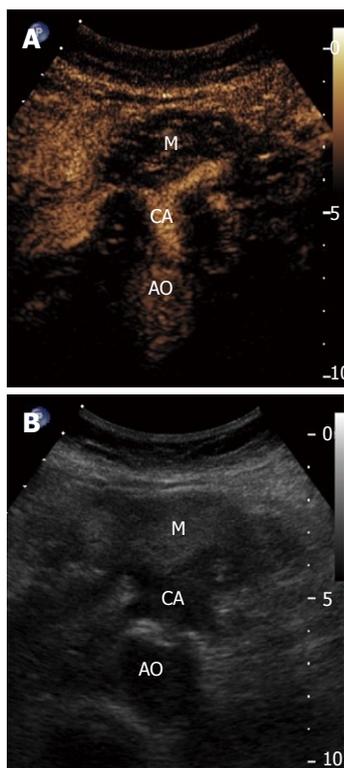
Transabdominal contrast enhanced ultrasound. A: Hypoechoic lesion in the head of the pancreas on traditional grey-scale ultrasound. B: Vascularity of this lesion after injection of Definity contrast agent. The ultimate diagnosis later proved to be pancreatic adenocarcinoma encasing the celiac axis. AO: aorta; CA: celiac axis; M: mass. Image courtesy of Dr. Stephanie Wilson, Department of Radiology, University of Calgary.
